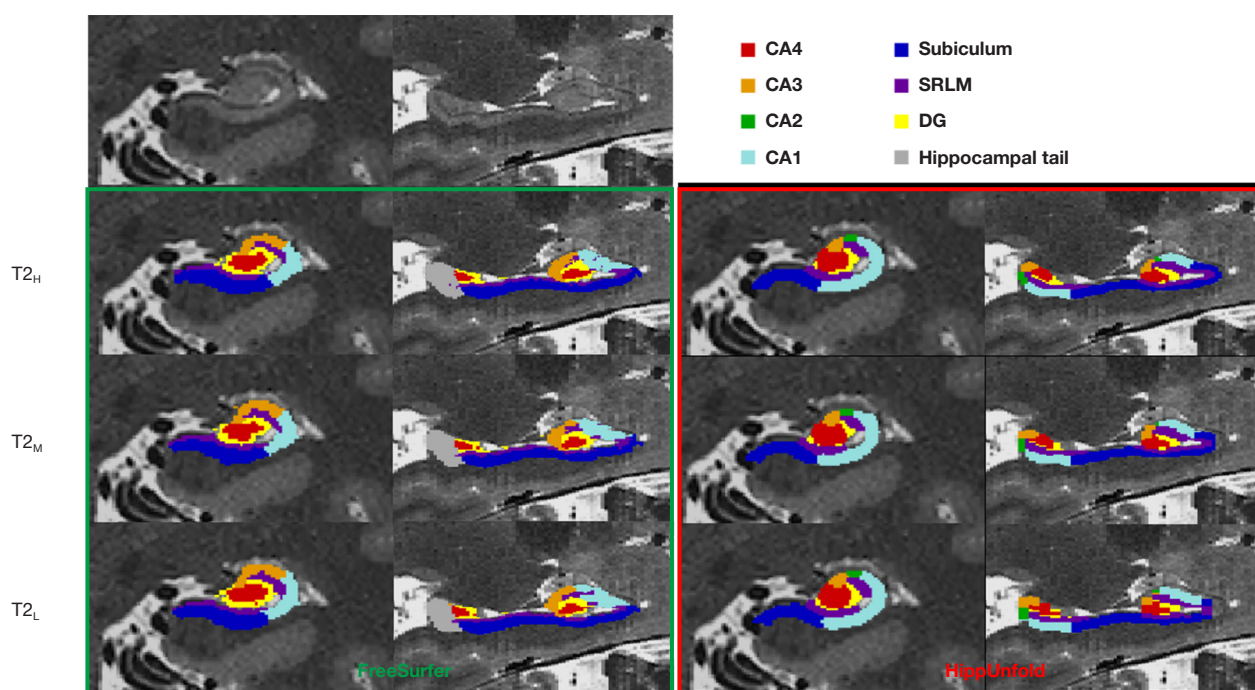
Subregion segmentation of the hippocampus from FreeSurfer (green box) and HippUnfold (red box) in a single participant. CA2 was included in CA3 in the FreeSurfer results. Hippocampal subfields were segmented with hippocampal tail in HippUnfold, while the hippocampal tail was a subfield part in FreeSurfer. T_{2H}, T_{2M}, and T_{2L}: T2-weighted images with slice thickness of 0.7, 1, and 2 mm, respectively. CA, cornu ammonis; DG, dentate gyrus; SRLM, stratum radiatum, lacunosum, and moleculare.
